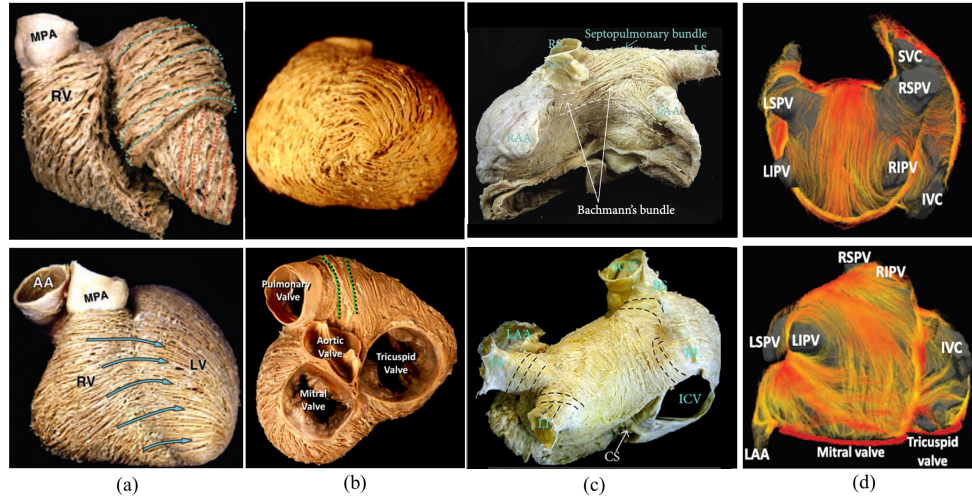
Anatomical dissection of myocardial fibers in ventricles (a-b) and atria (c). Atrial fibers revealed by sub-millimeter *Diffusion Tensor Magnetic Resonance Imaging*, DT-MRI (d). Images taken from [214, 212, 167].
